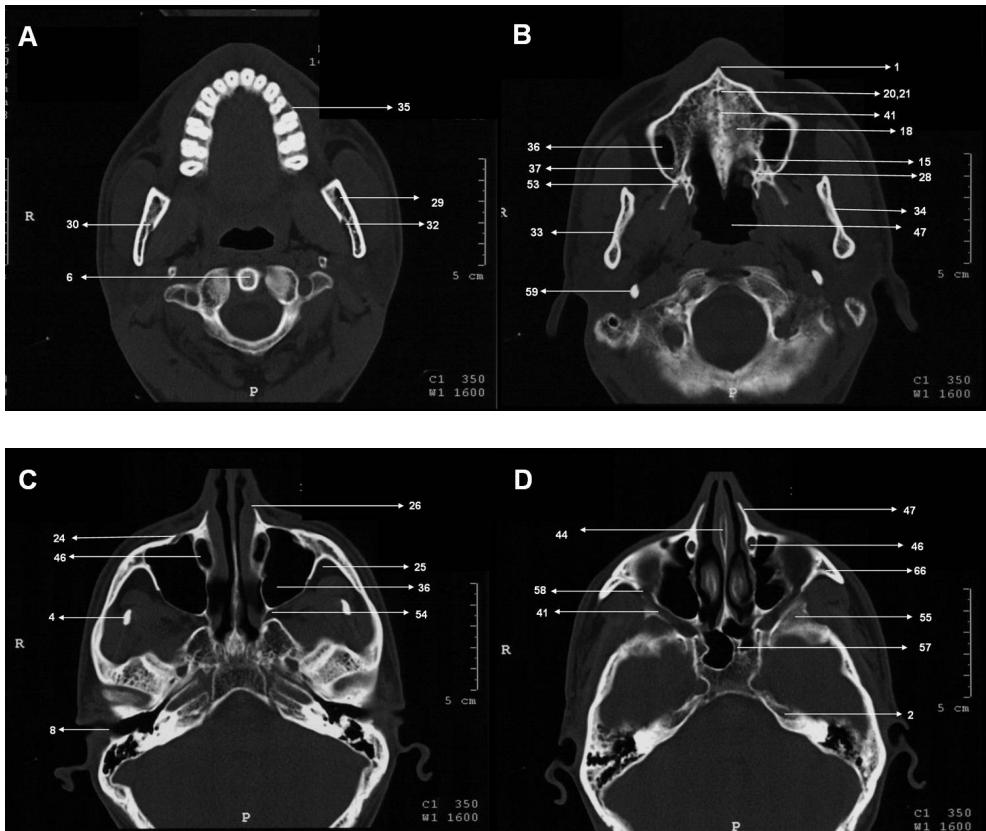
(A,B). Axial CT anatomy of the facial skeleton; (C,D). Axial CT anatomy of the facial skeleton
